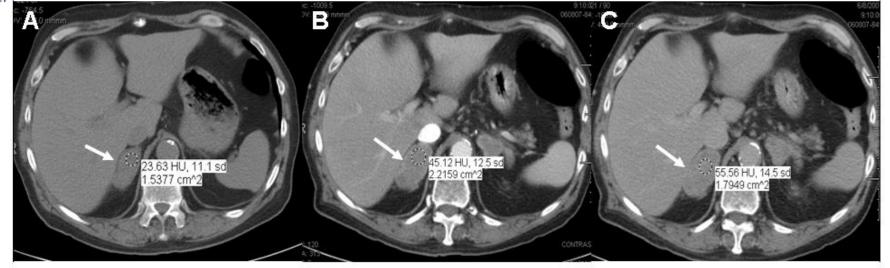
Abdominal CT of bilateral adrenal masses (arrow) shows persistent enhancement of the right adrenal gland after intravenous contrast at 1.5 (panel B) and 5 min (panel C) after contrast injection in a pattern compatible with metastases to the adrenals.
